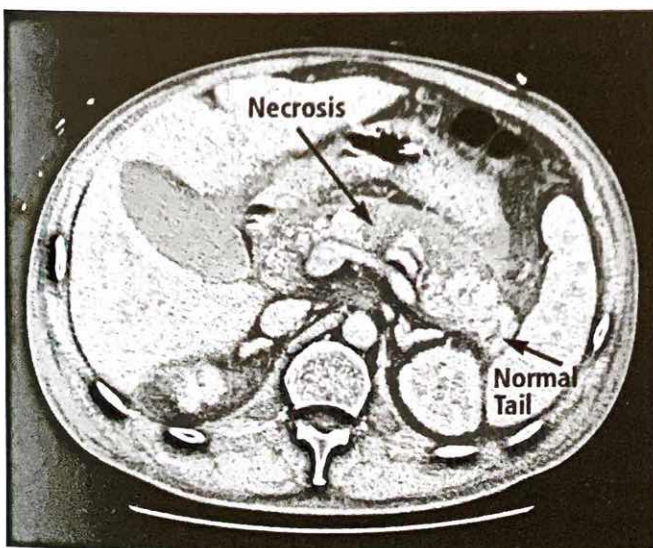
CT scan showing acute pancreatitis with hypoperfusion of the body of the pancreas, as indicated by lack of enhancement following intravenous contrast infusion (necrosis) and normal perfusion of the pancreatic tail.
